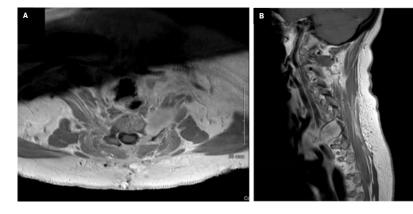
Contrast-enhanced MRI of the cervical spine demonstrating a postoperative residual tumor in the anterior region adjacent to the brachial plexus. (A) Axial T1 sequence with contrast; (B) sagittal T1 sequence with contrast.
